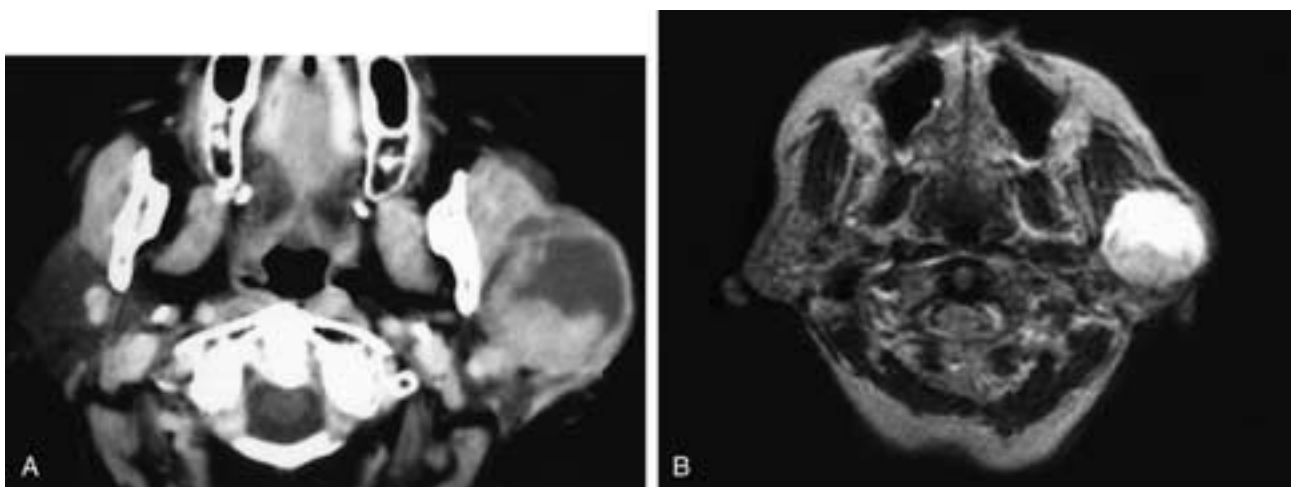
Axial contrast-enhanced CT scan (A) and T2-weighted MR image (B) show a partially cystic mass in the left parotid gland. The noncystic region is the residual tumor mass. This patient had a Warthin's tumor.
